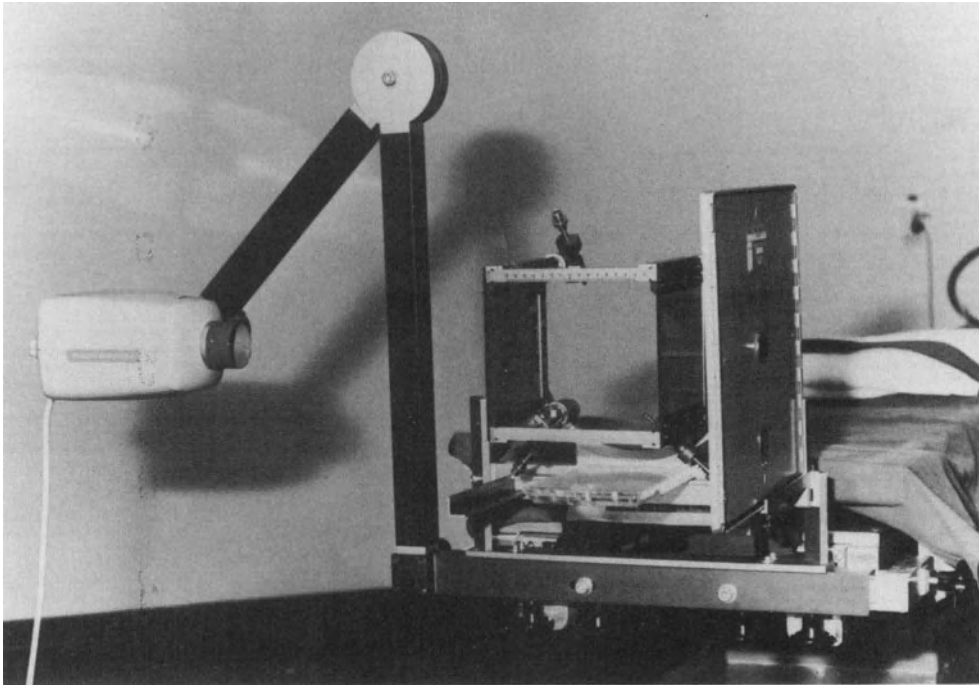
The table-mounted, short-distance radiography unit.
